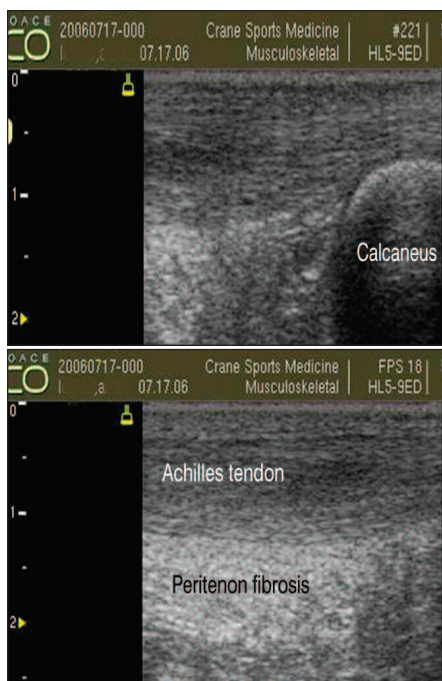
Diagnostic ultrasound of the left achilles (proximal and distal) showing a large hypoechoic noninsertional tendonosis with surrounding fibrosis.
